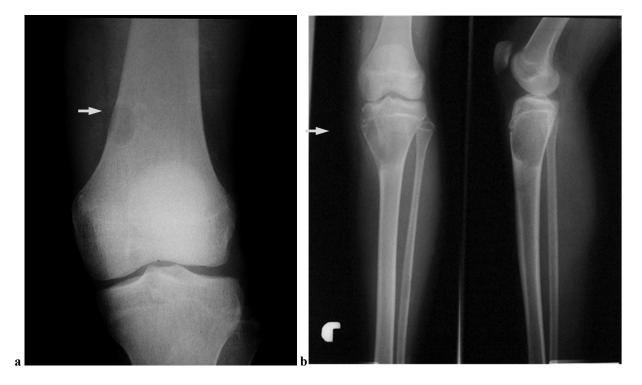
a) distal femur non ossifying fibroma ("leave me alone" lesion), b) aneurismal bone cyst of proximal tibia ("active bone cyst"), c) proximal medial tibia osteochondroma, d) x-ray and MRI of distal femur osterosarcoma.
